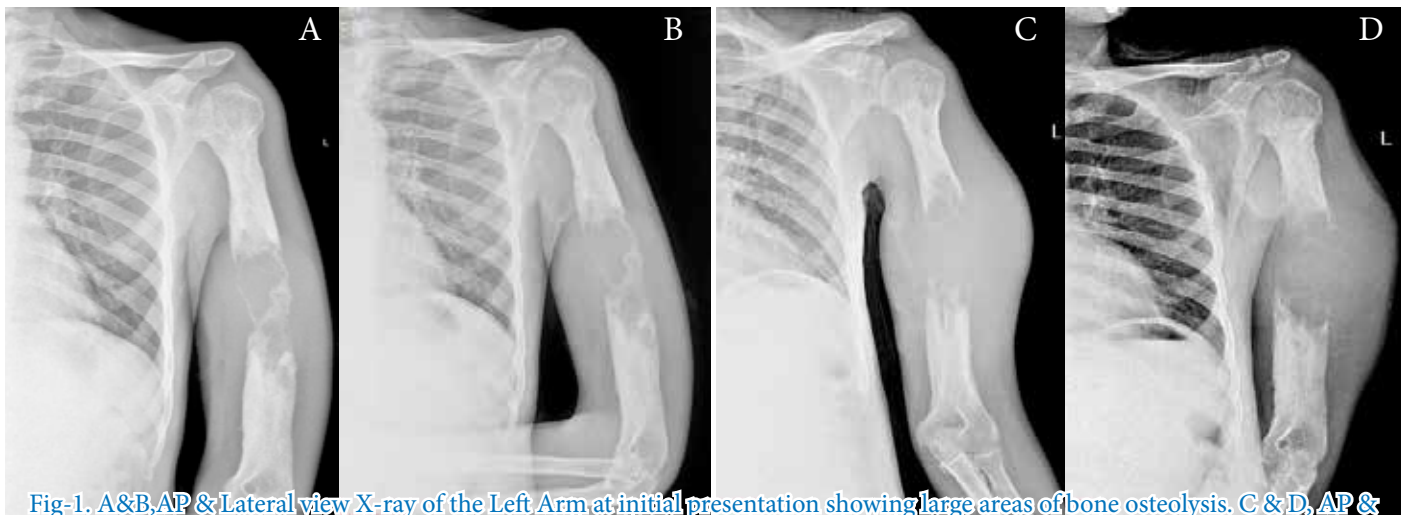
A&B, AP & Lateral view X-ray of the Left Arm at initial presentation showing large areas of bone osteolysis. C & D, AP & Lateral view X-ray 2months after presentation showing larger area of osteolysis with soft tissue mass.
